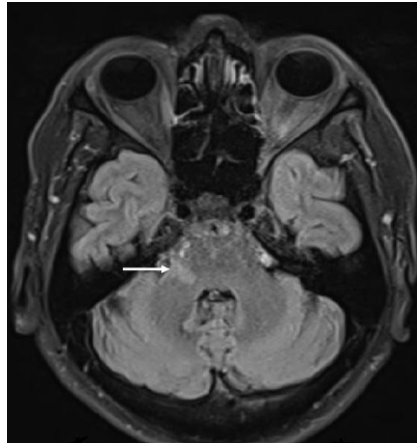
FLAIR axial section showing hyperintense signal in root zone of right trigeminal nerve in pons (arrow).
